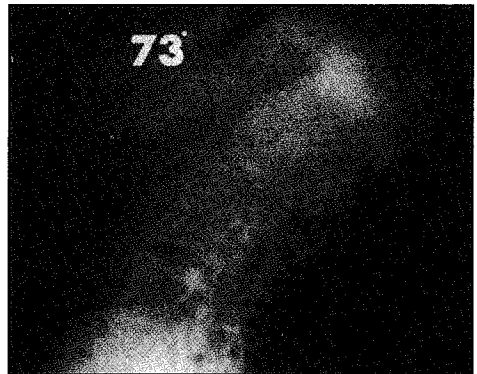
Pre operative lateral radiograph shows the sagittal curve has progressed to 73 degrees.
